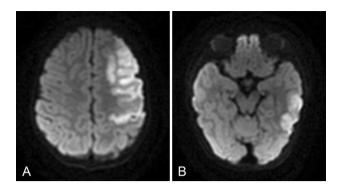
Axial view of a diffusion-weighted magnetic resonance imaging (DW-MRI) showing a large infarct in the left fronto-temporoparietal region (A) and a small infarct in the left temporal lobe posteriorly (B)
